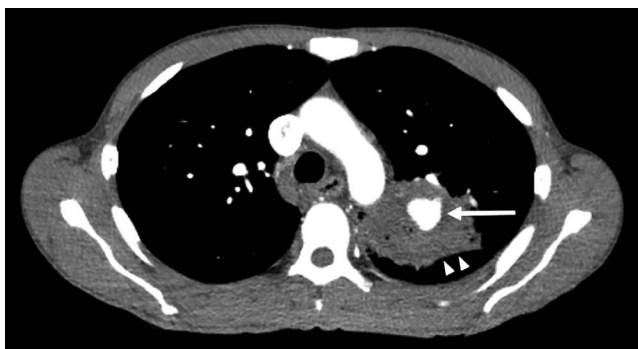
Axial computed tomography angiography image demonstrates a 2.6 \times 2.0 \times 1.8-cm lobular focus (arrow) with avid arterial phase enhancement situated within a partially cavitary mass (arrowheads) in the apical portion of the left lung. Enhancement of this saccular lesion is equal to that of adjacent arteries.
